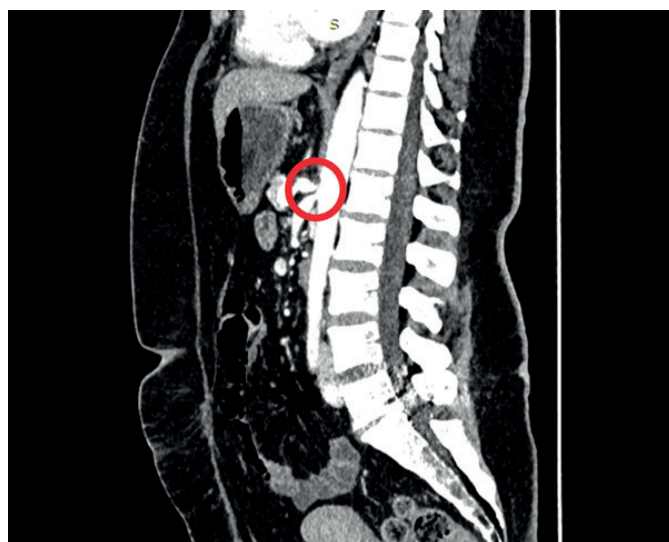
CT of the abdomen, sagittal view
